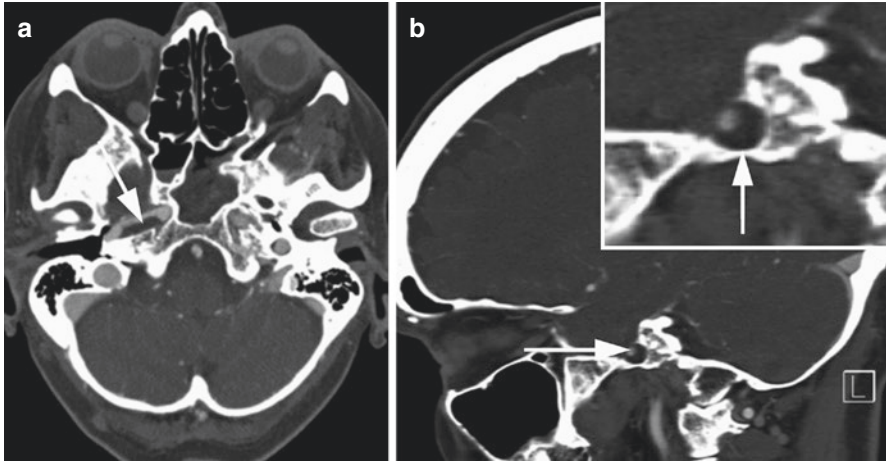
Petrous internal carotid artery dissection. Patient presenting with right hemispheric stroke and right petrous ICA dissection. Axial (a) and sagittal (b, inset) CTA showed 50% lumen narrowing and intramural hematoma (arrows) indicating dissection of the right petrous ICA
